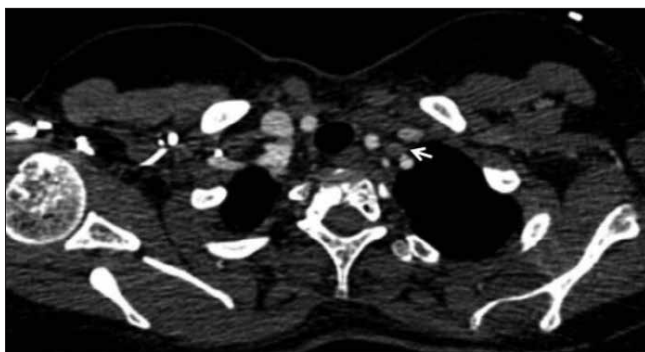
Thrombosed external jugular vein (white arrow) is observed in the anterior segment of the left vertebral artery on the axial thorax computed tomography fraction with contrast agent
